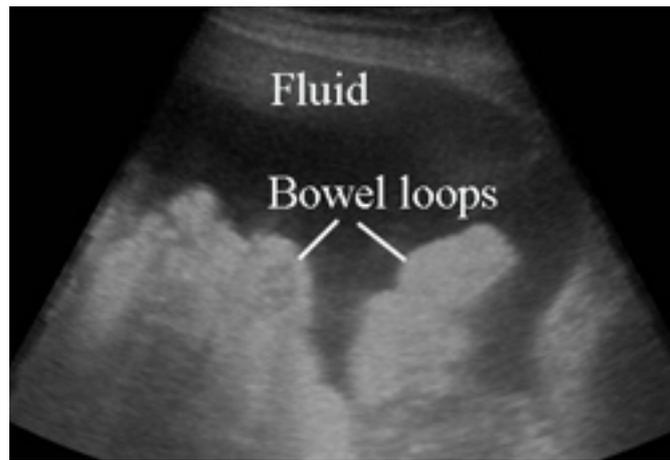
Abdominal ultrasound showing large amount of ascites with bowel loops
